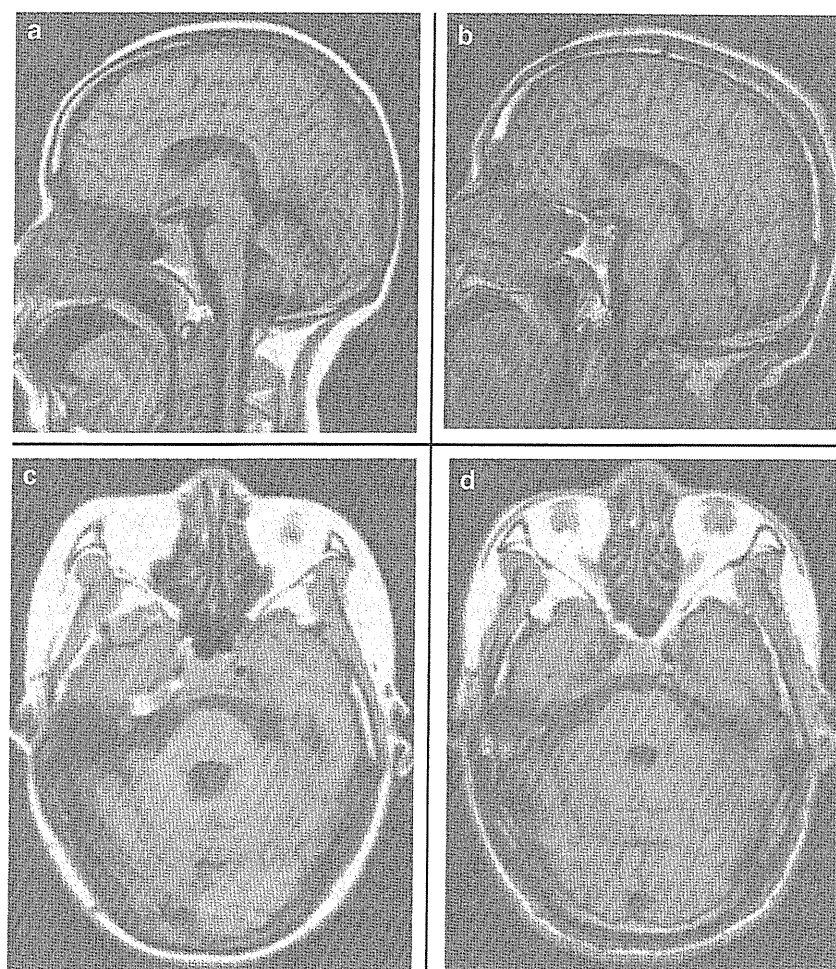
T1-weighted magnetic resonance imaging (MRI) of IV-4 (a, c) and IV-5 (b, d). Patient IV-4 showed marked cerebellar atrophy, and patient IV-5 showed no cerebellar atrophy.
